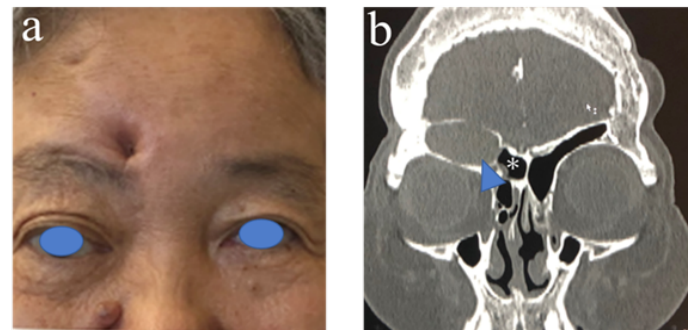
Initial findings. a) Photograph of the forehead. The external fistula is located in the depression in the right forehead. b) CT coronal section of the sinuses. A frontal sinus mucocoele (arrowhead) is seen lateral to an internal septal cell (ISSC) (*) located to the right of the midline.
